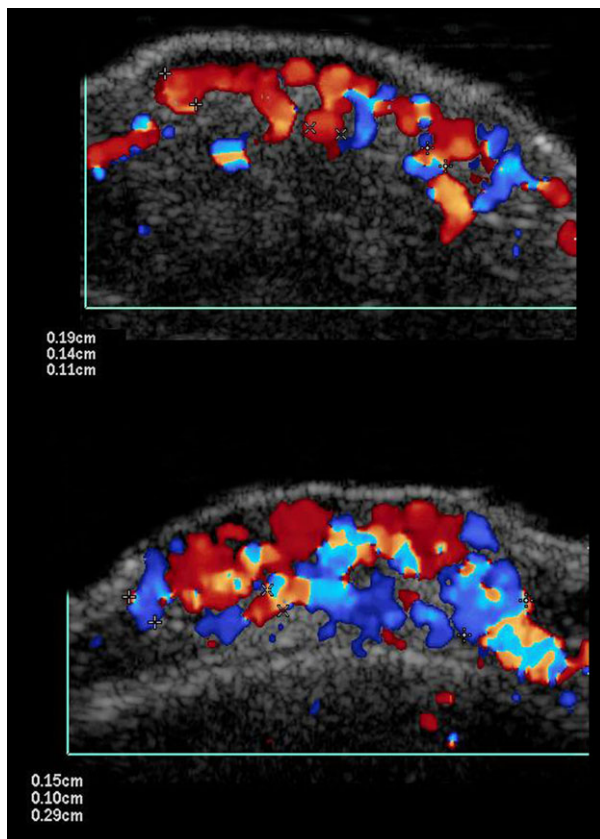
Examples of color Doppler ultrasound measurements of maximum thickness of the intralesional vessels in two cases with infantile hemangiomas (transverse axes). The measurements that have been selected for recording were 1.9 mm (top) and 2.9 mm (bottom).
